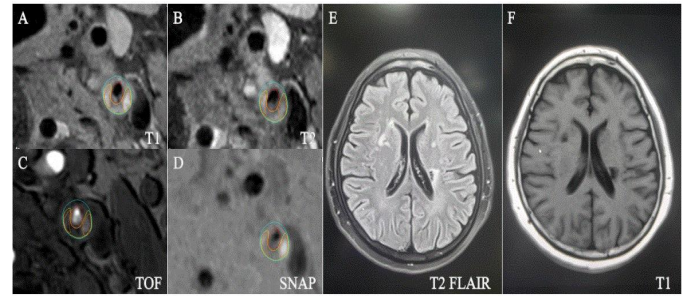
A patient with moderate stenosis in left carotid artery had mild LAC. A-D HR-MRI reveal a plaque with multiple components, including LRNC and IPH. E-F LAC can be clearly observed on T1 and T2 FLAIR images.
